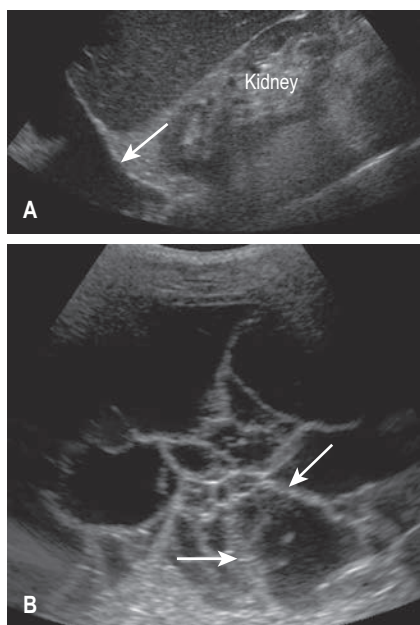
(A) and (B) Ultrasound of a parapneumonic effusion showing septations (arrows) within the fluid consistent with an empyema. (Reproduced with permission from Seely J, Ayyappan A. Pleural effusion. In: Muller NL, Silva IS, eds. *Imaging of the Chest*. Philadelphia. Saunders/Elsevier; 2008:1341–1342.)
